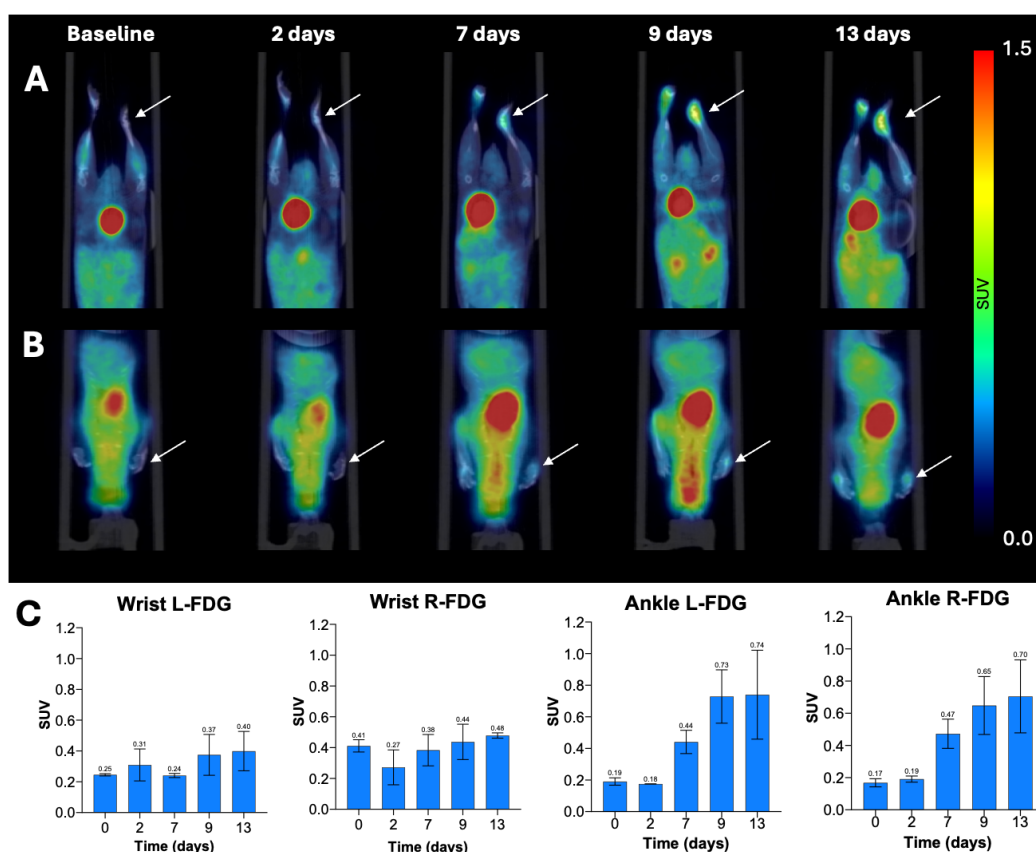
Longitudinal assessment of [^{18}F]FDG SUV joint following arthritis induction. (A): PET images of affected ankles at five time points: baseline (day 0), and days 2, 7, 9, and 13 post-inductions. (B): PET images of affected wrist at five time points: baseline (day 0), and days 2, 7, 9, and 13 post-inductions. (C): Quantitative analysis of joint, represented by the mean uptake (in SUV) of the left wrist, right wrist, right ankle, and left ankle at the corresponding time points.
